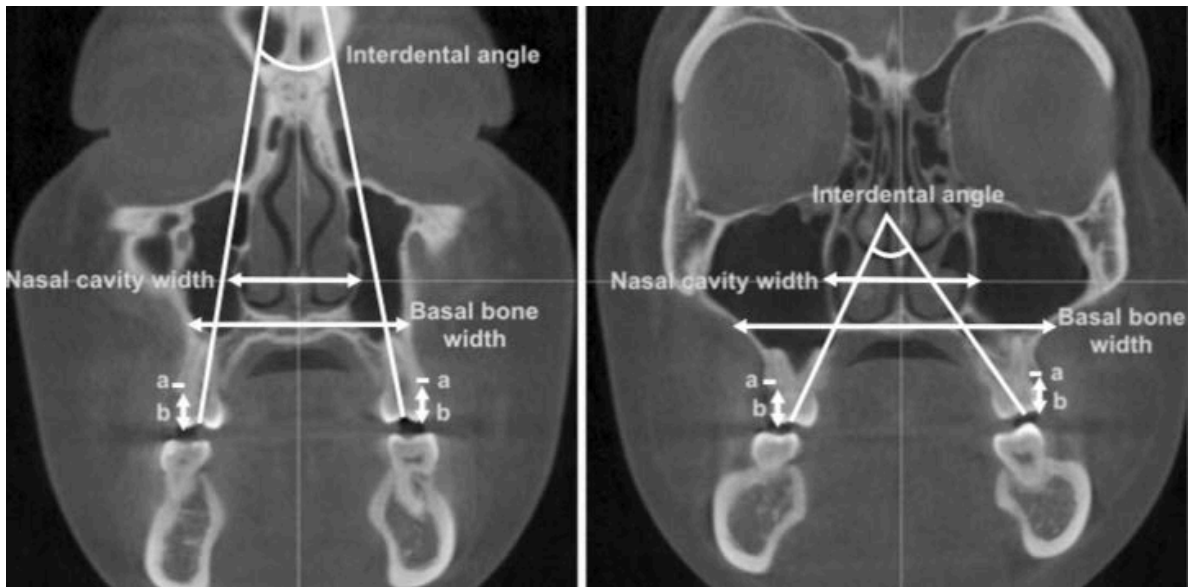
Study by Park et al.: Coronal cone-beam computed tomography images acquired before expansion at furcations of the first premolar (left) and first molar (right). (65)
